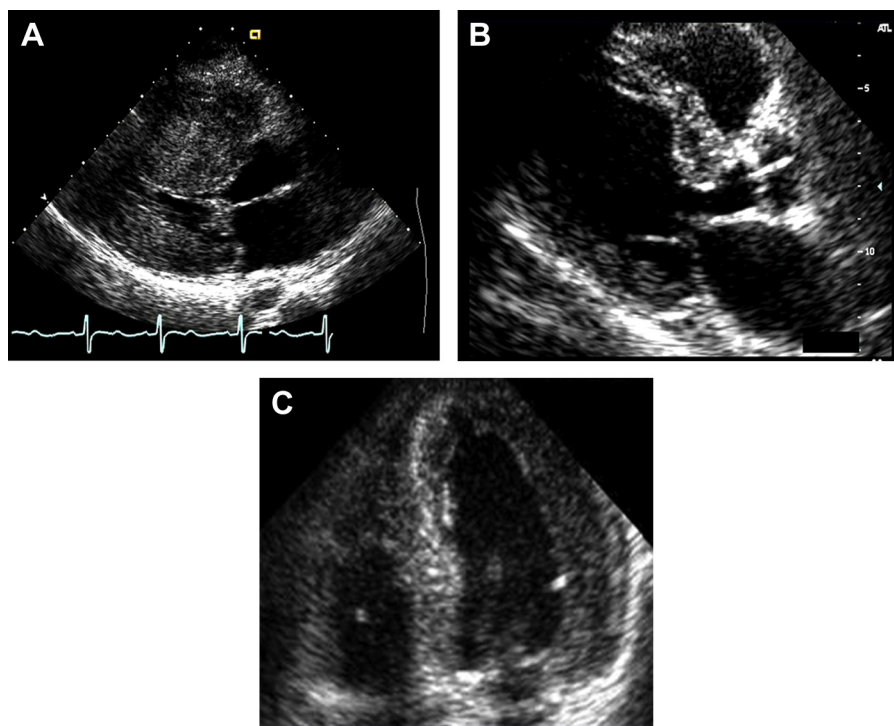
(A) Parasternal long-axis echocardiographic image in a patient with RSC. Notice the predominant midseptal convexity toward the LV cavity, with the cavity having a crescentic shape. (B) Parasternal long-axis echocardiographic image in an older hypertensive patient with sigmoid septum. Notice the ovoid cavity with the septum being concave toward the LV with a pronounced basal septal bulge, and (C) 4-chamber echocardiographic image in a patient with CH, where there was a similar degree of hypertrophy throughout the LV. All patients had severe resting or provokable LV outflow tract gradient, requiring surgical myectomy.
